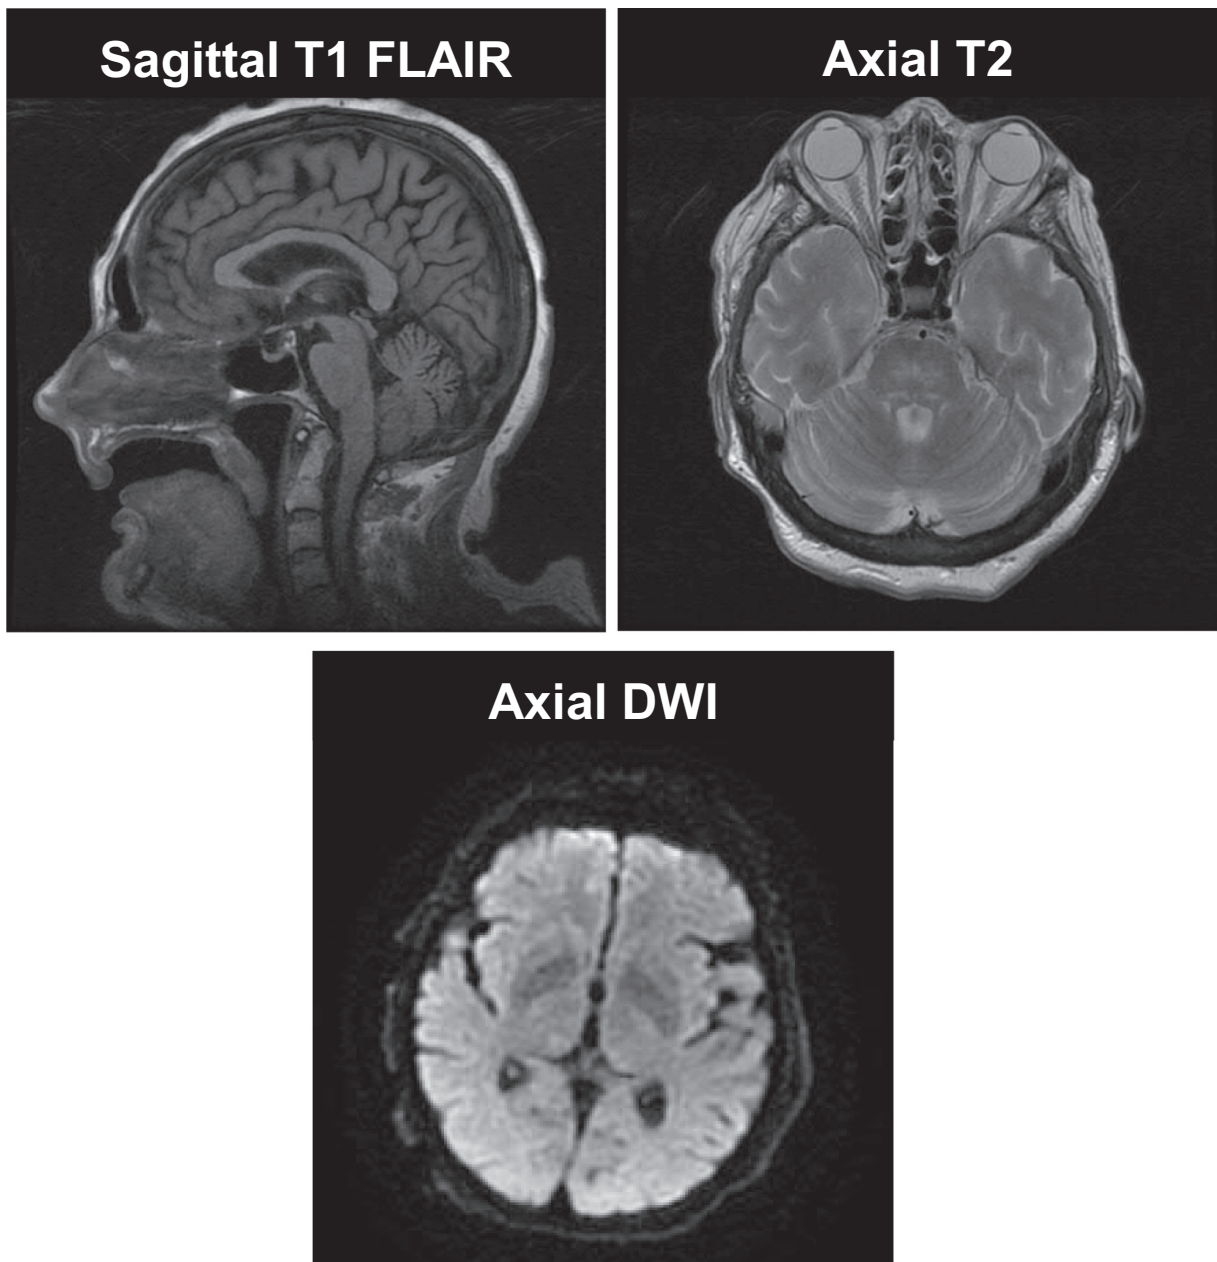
Representative images of patient's brain MRI. There was no evidence of hemorrhage, infarct, or other acute intracranial abnormalities.
